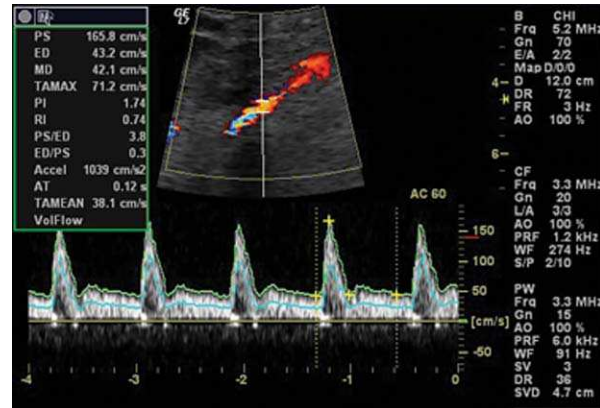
Duplex Doppler sonography of a patient with mesenteric panniculitis shows a low-resistance waveform in the superior mesenteric artery with continuous forward diastolic flow. The blood flow is higher than 1200 mL/min. Abbreviations are as in Figure 3.
